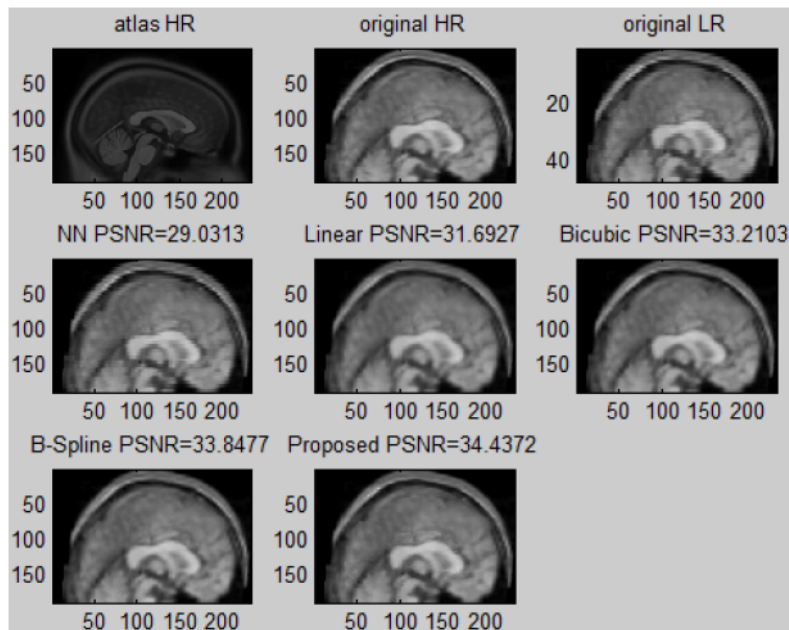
A sagittal slice results with slice thickness = 4 of real MRI
